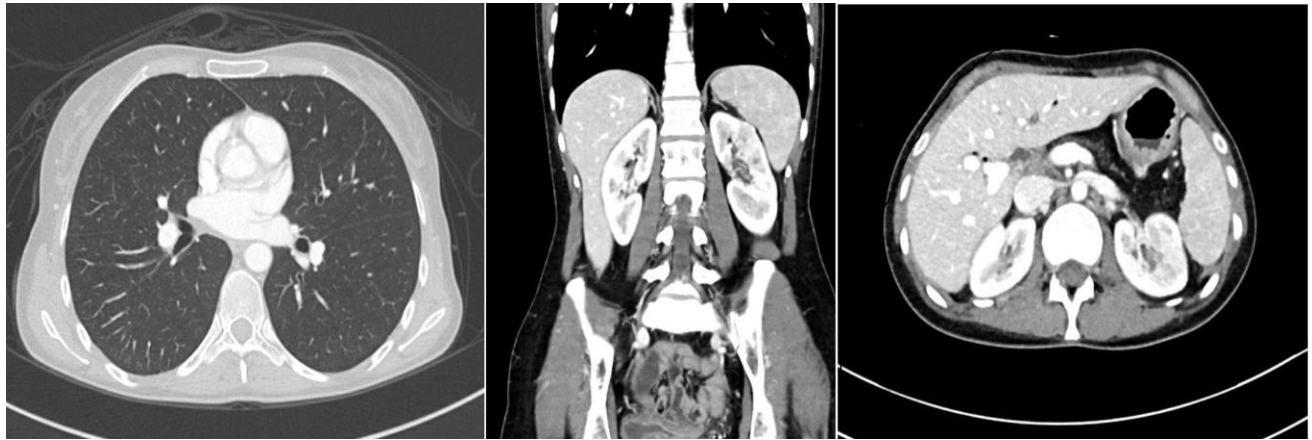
CT chest and abdomen after treatment
